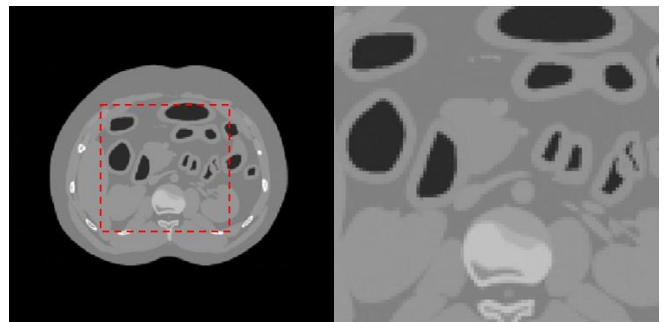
(a) Sample abdomen CT image (left) and (b) region of interest extracted from the red dotted square (right).
